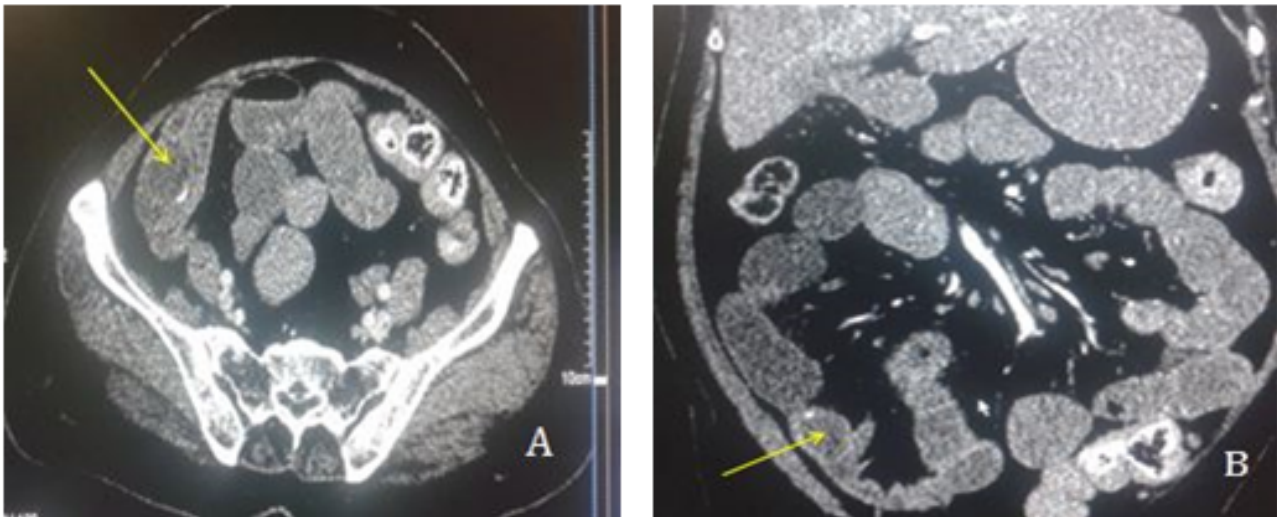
(A, B): Axial (A) and coronal (B) sections of abdominal computed tomography show an ectopic stone in distal ileum
